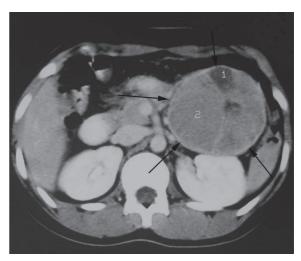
Solid papillary epithelial neoplasm (SPEN) in a 20-year-old female. CT shows a predominantly solid mass with minimal hemorrhagic, cystic component at the pancreatic tail (arrows).
